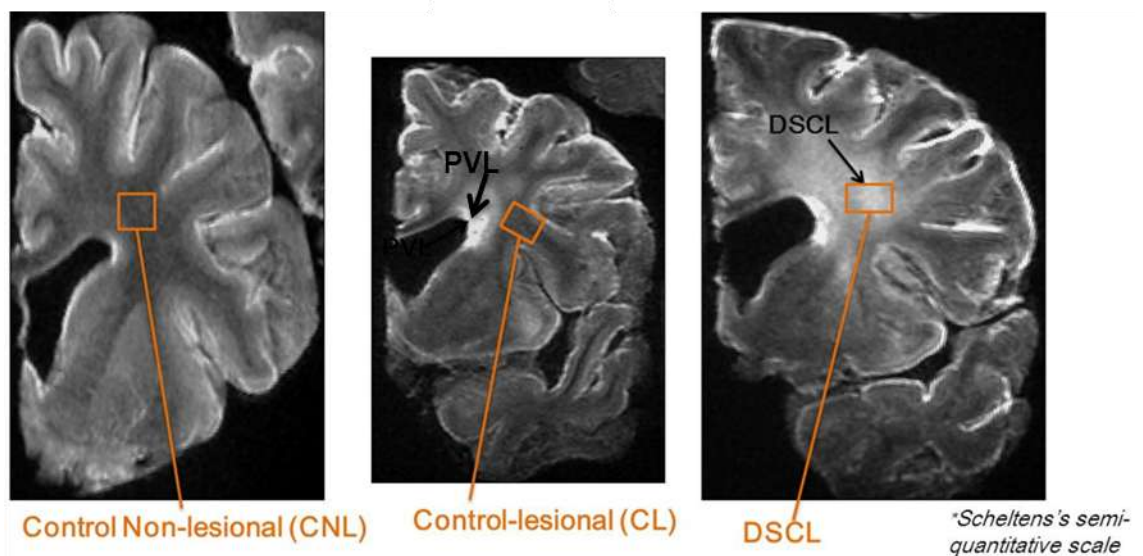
WML identification and anatomical classification using MRI scans. Left: MRI scan of a control coronal brain slice free of lesion. Middle: Coronal brain slice showing a periventricular WML shown as hyperintensity in MRI signal. The orange frame shows an area that is free of lesion in a lesional brain. Right: A coronal brain slice showing hyperintensity MRI scan demonstrating a deep subcortical white matter lesion
